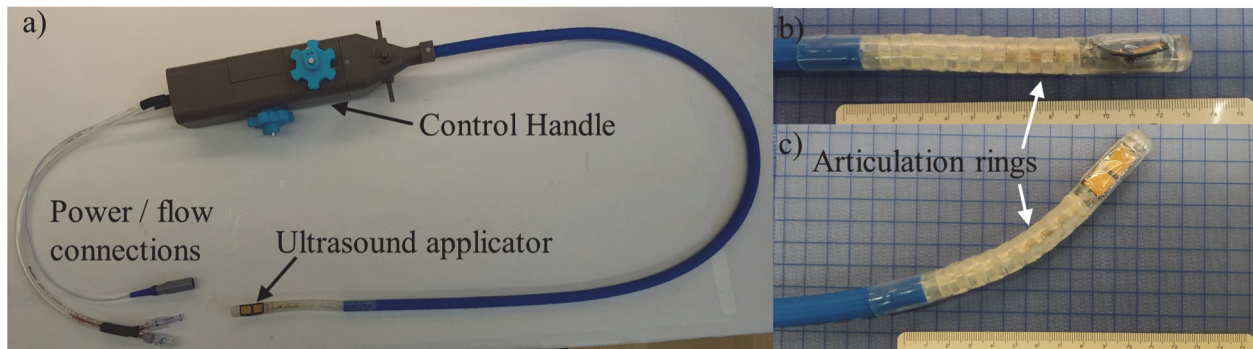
(a) Prototype endoluminal ultrasound applicator with endoscopic tip articulation capabilities. (b) Distal tip of the assembly, highlighting the ultrasound applicator and articulation ring segment in neutral and (c) bent states.
